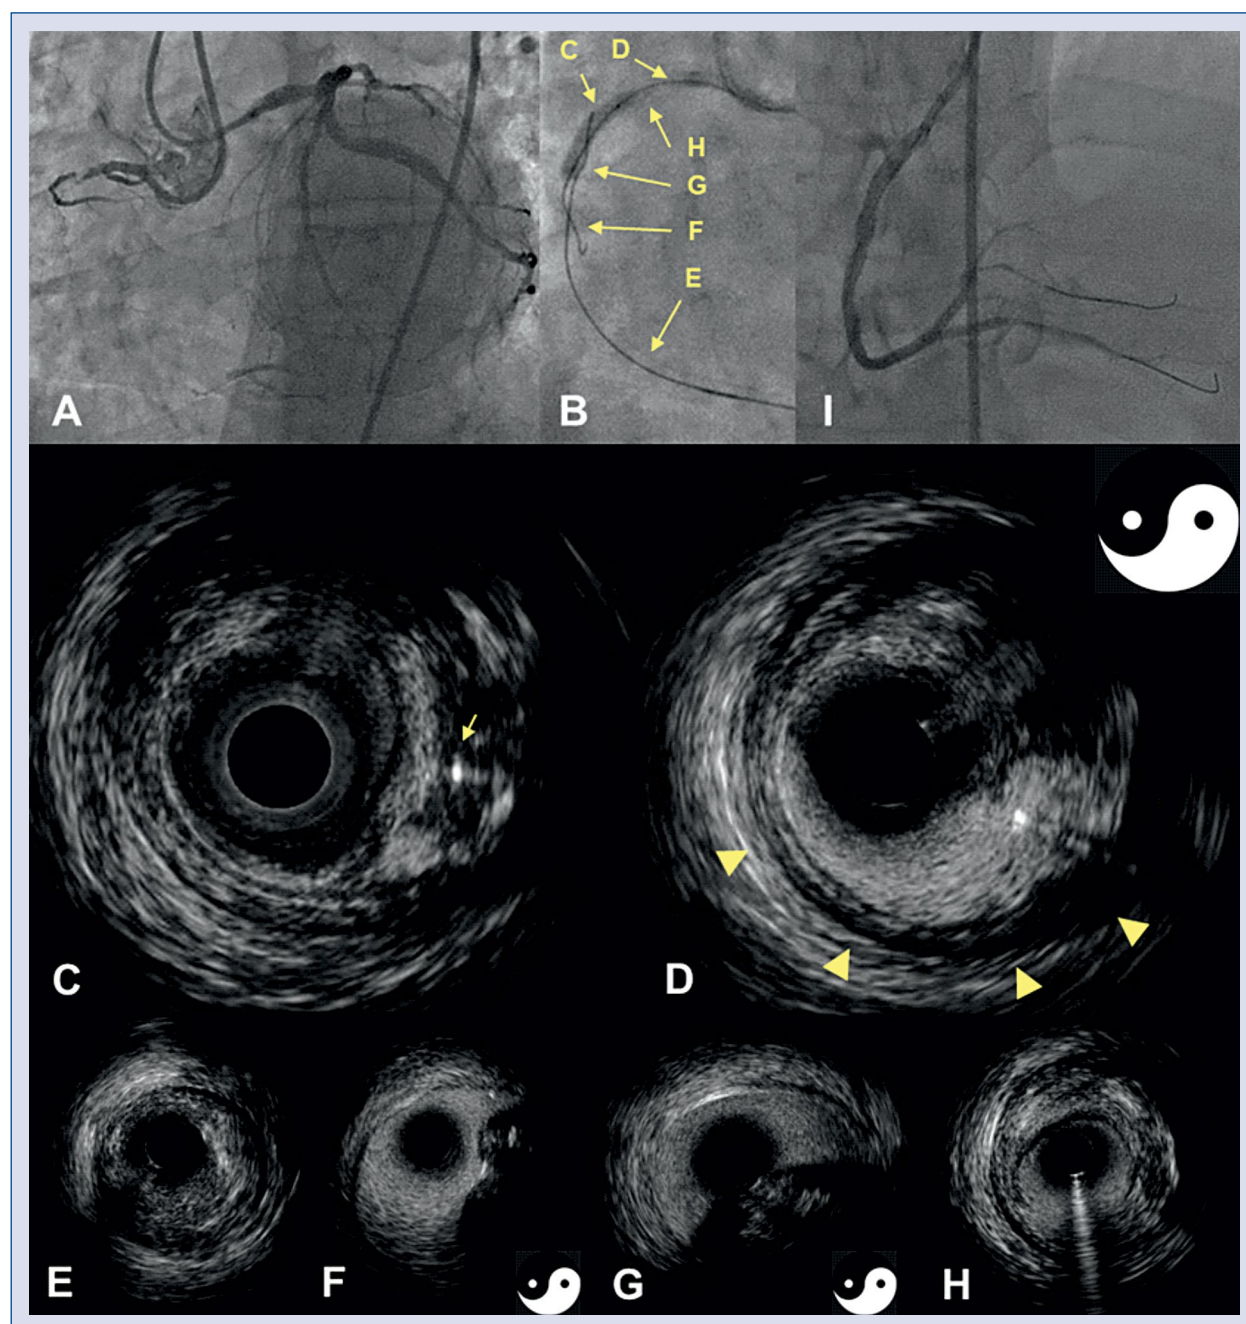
A chronic total occlusion of the proximal right coronary artery (A) was percutaneously treated via the retrograde approach with controlled-antegrade-retrograde tracking (rCART) technique (B), but the retrograde wire had problems externalizing. Intravascular ultrasound (IVUS)-guided rCART was then performed with a 60 MHz high definition IVUS (C, D), finding a scenario of antegrade intraplaque/retrograde subintimal (C, arrow; D, arrow heads). Since the speckle of static blood appears enhanced in 60 MHz IVUS as compared to lower frequencies, the subintimal hematoma appears whitish (D), producing a characteristic yin-yang sign: the anatomy of the vessel appears divided in two, with one half dark (true lumen/intraplaque) and the other half whitish (subintimal). After externalization of the wire a final 60-MHz IVUS pullback was acquired (E–H). The yin-yang sign (F, G) enables unambiguous and accurate recognition of the subintimal course. An excellent final result was, in the end, achieved (I).
